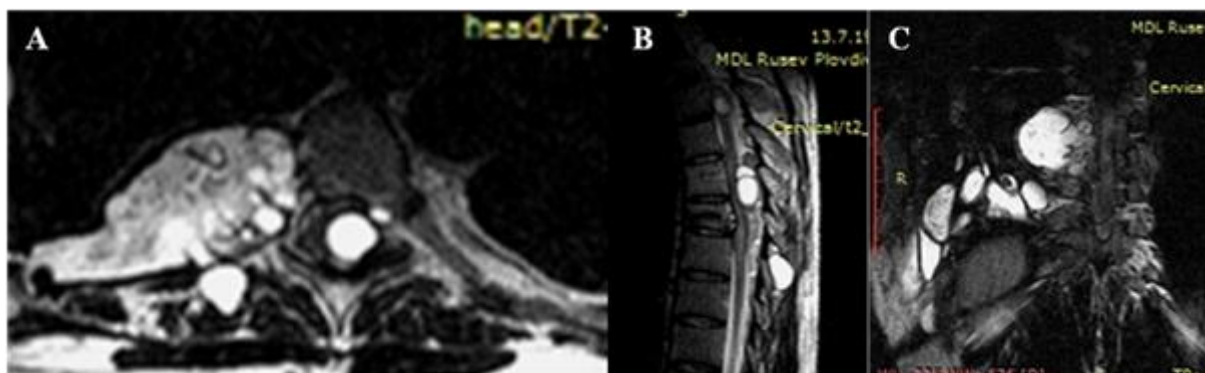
MRI images of spinal echinococcosis in the thoracic region:
